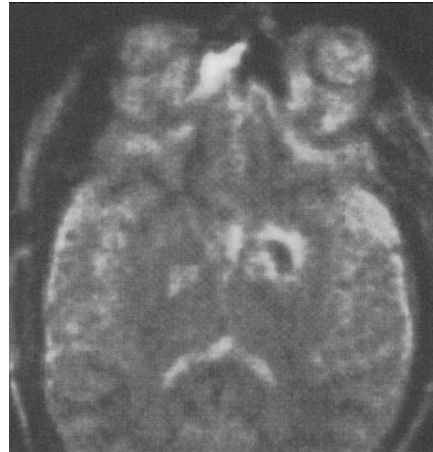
T2 MRI (TR 2000, TE 105) demonstrating decreased signal intensity in a hemorrhagic focus. (Image from a Toshiba 0.64-T open-design MR system)
